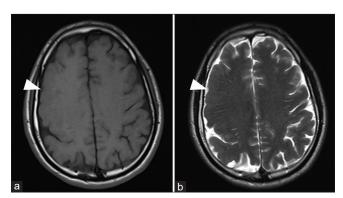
Magnetic resonance imaging demonstrated showed decreased cerebral convolutions and focal thickened cortex over the right frontoparietal lobe (arrow head) consistent with pachygyria. (a) T1-weighted sequences; (b) T2-weighted sequences.
